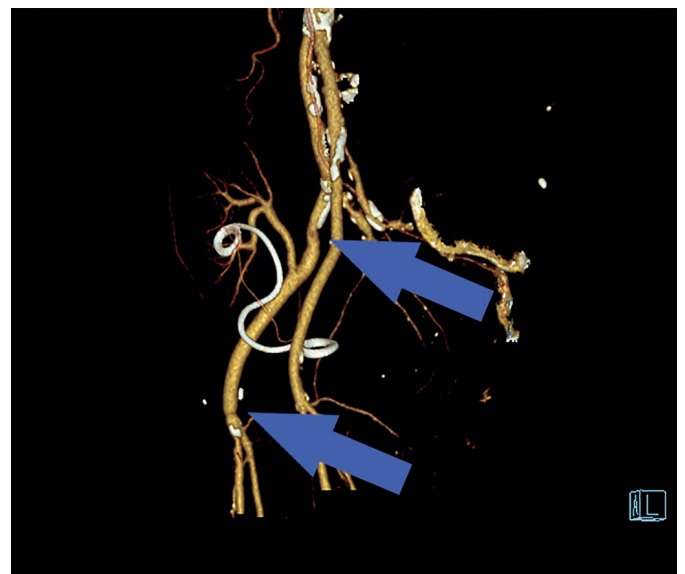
CT arteriography showing ilio-femoral bypass (blue arrows) with normal allograft perfusion.
